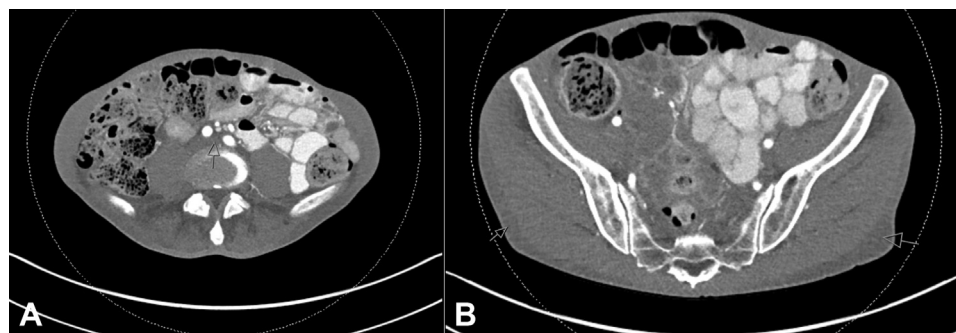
Computed tomography scans of abdomen/pelvis showing (A) diffuse subcutaneous anasarca with (B) notable mesenteric/retroperitoneal edema.
